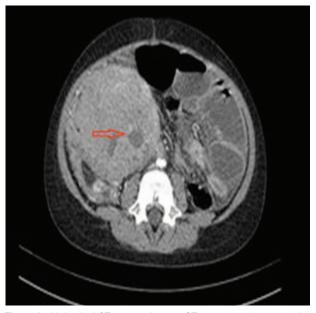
Abdominal CT-tumoral mass. CT = computed tomography.
